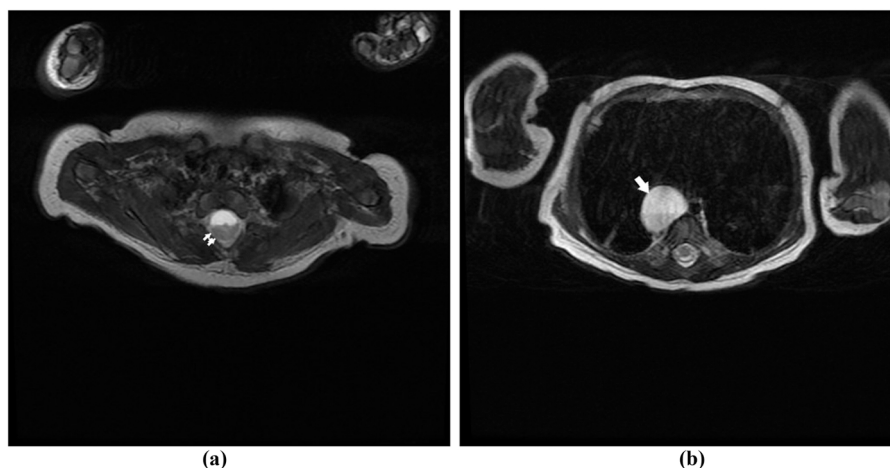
MRI axial cervical (C7 level) (Fig. 1a) and axial thoracic (T8 level) (Fig. 1b) T2W sequence images. Both cysts are hyperintense on T2. The intraspinal component is intradural, extramedullary. Notice its ventral location in relation to the spinal cord (double arrows on the cord, single arrow on the mediastinal cyst).
